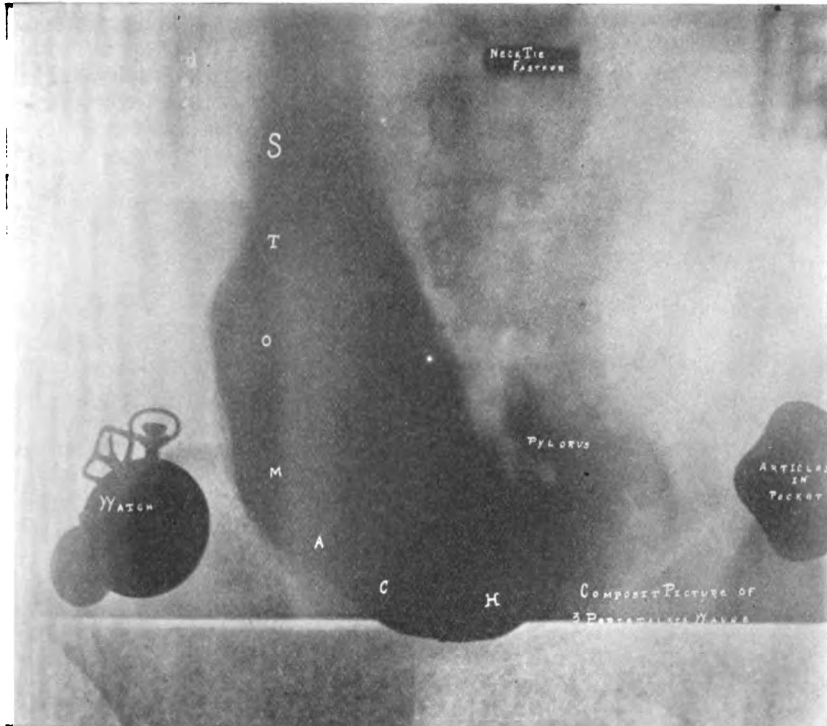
Radiograph of stomach through the clothes.
